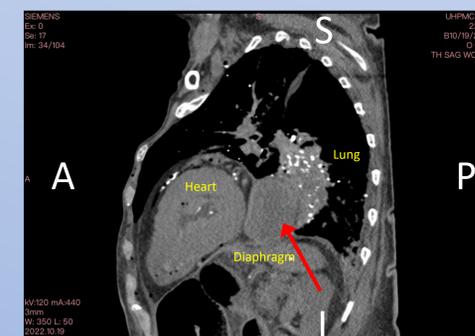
CT oblique sagittal view of hiatal hernia (red arrow).
